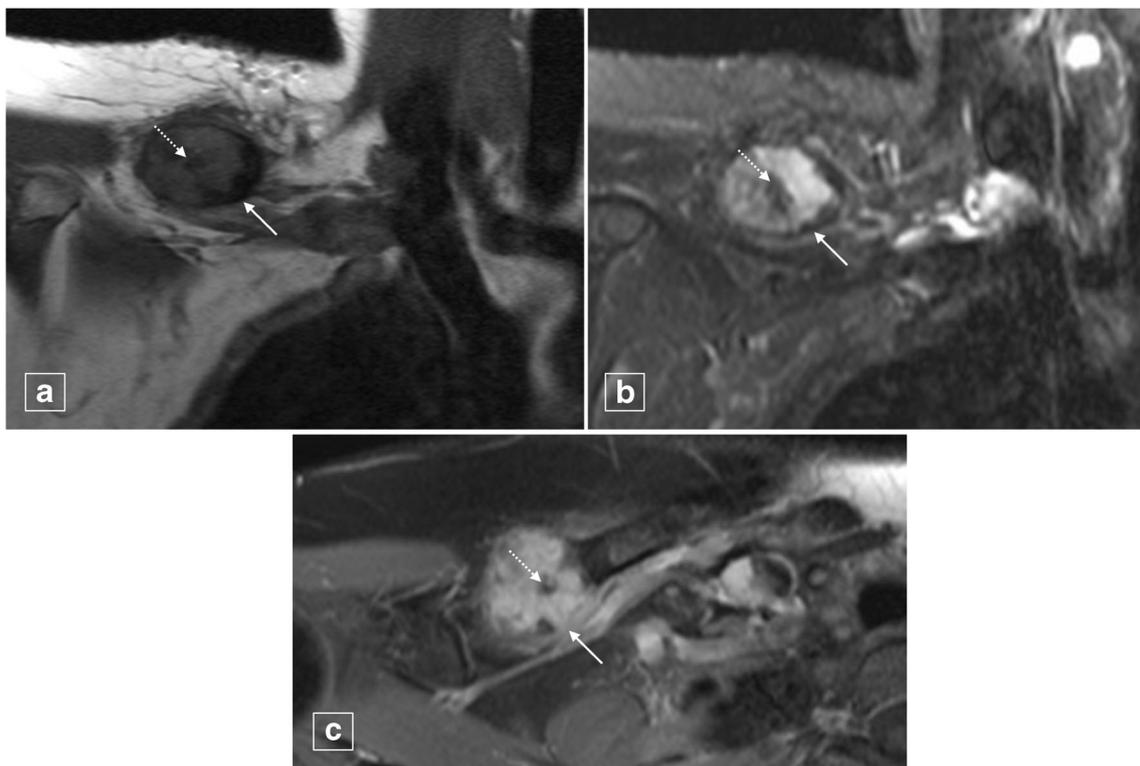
MRI demonstrating an expansile and lobulated lesion (solid arrows) centered in the right mid clavicle with heterogeneous hypointense signal on T1-weighted images (a) and hyperintense signal T2-weighted images (b). After intravenous gadolinium administration
